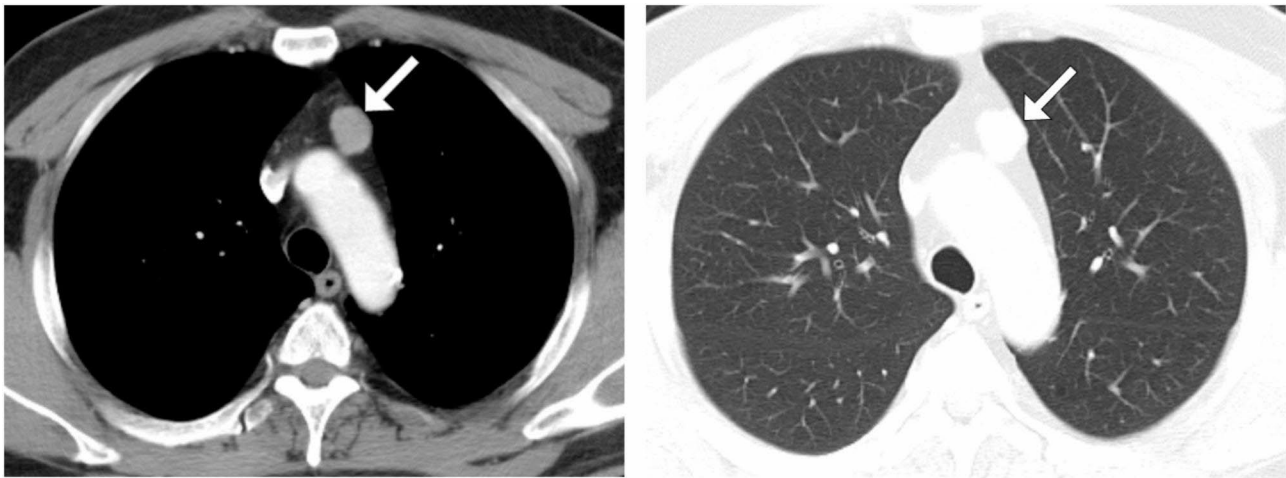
Contrast-enhanced mediastinal CT scan demonstrating a 23*21 mm soft tissue mass with homogeneous in the anterior mediastinum, consistent with thymoma
